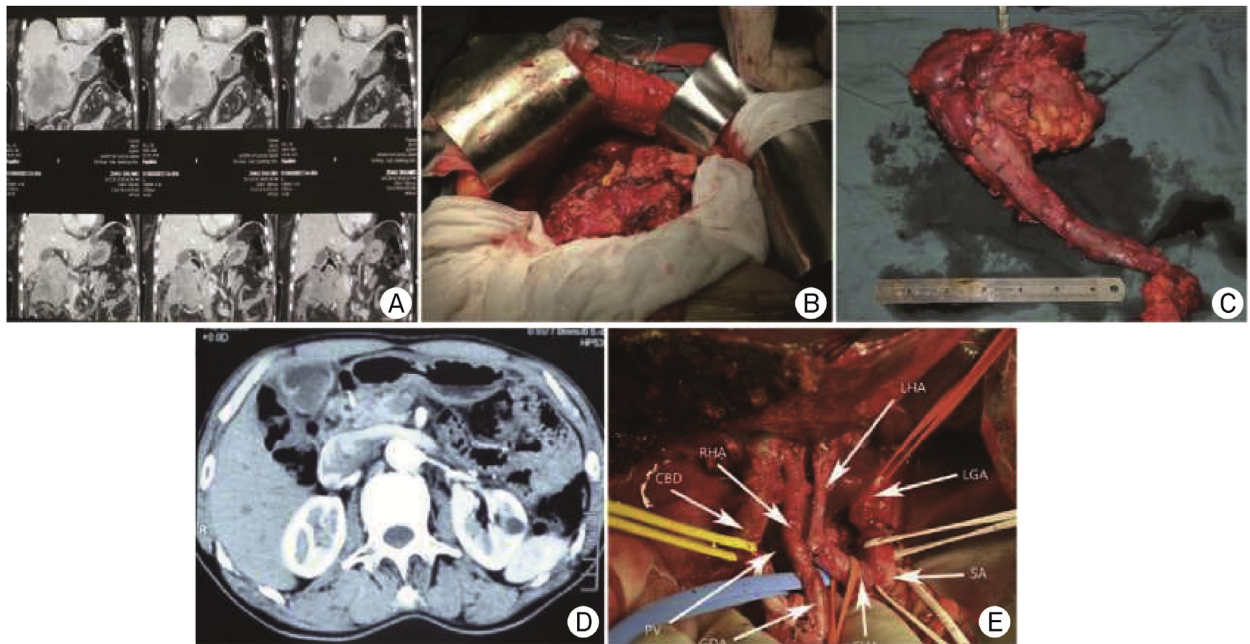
R0 resection of patients with stage IV gallbladder cancer (GBC). (A–C) Hepatic pancreatoduodenectomy for T4N1M0 GBC. (A) Preoperative CT image; (B) investigation during surgery; (C) the resected tumor and adjacent organ. (D–E) Radical resection for T3N2M0 GBC. (D) Preoperative CT image; (E) the extended lymphadenectomy.
